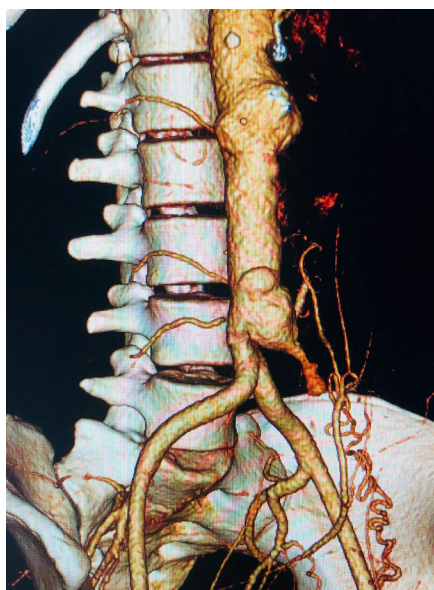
Three-dimensional CT angiogram showing a distal aortic rupture and the bilateral ostial occlusion of the renal artery.
